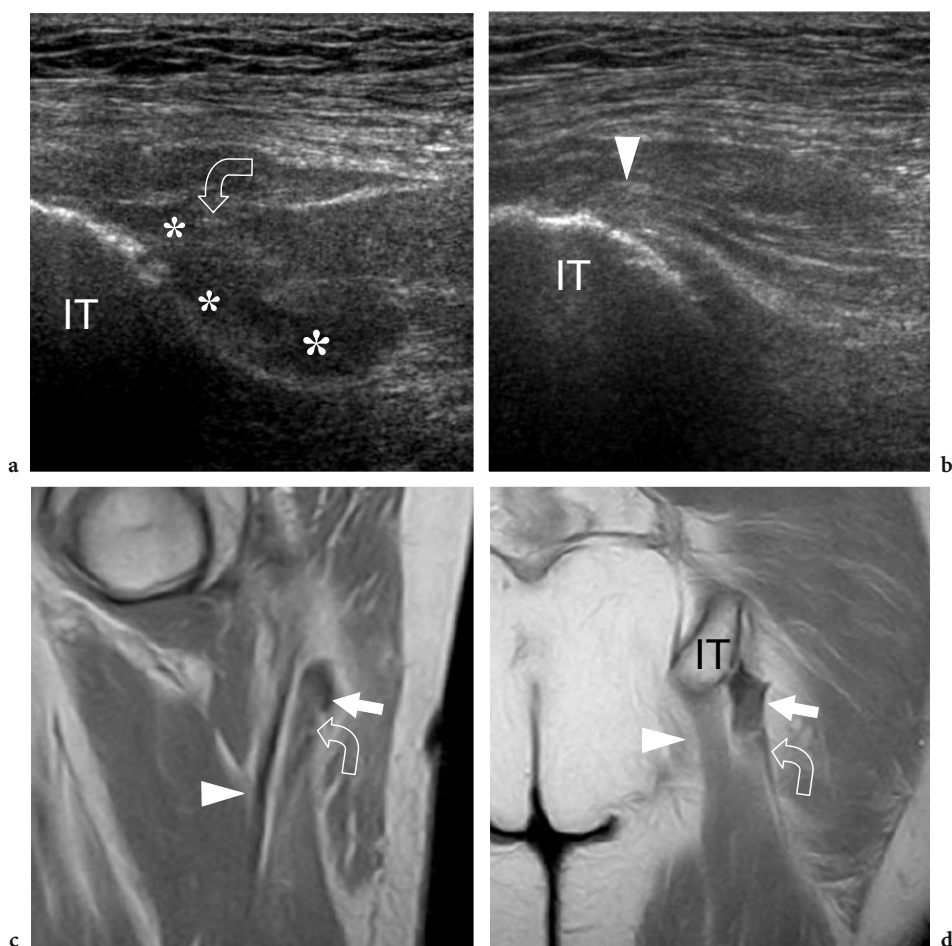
Avulsion tear of the semitendinosus-biceps tendon. a,b Long-axis 12–5 MHz US images over a the conjoint semitendinosus-biceps tendon and b the semimembranosus tendon. While the conjoint tendon (*curved arrow*) is avulsed from its insertion on the ischial tuberosity (*IT*) and appears surrounded by hypoechoic hematoma (*asterisks*), the semimembranosus tendon (*arrowhead*) appears intact. c,d Coronal Gd-enhanced T1-weighted MR images confirm the complete tear of the semitendinosus-biceps tendon complex (*curved arrow*) and the hematoma (*straight arrow*) which separates it from the ischial tuberosity (*IT*). In both MR images, note the normal-appearing semimembranosus tendon (*arrowhead*)
